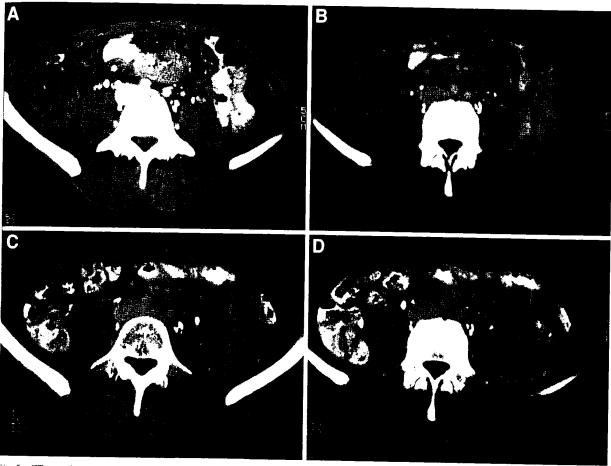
CT scan images of patient 8 from two comparable levels before treatment (A and B) and 5 months after treatment (C and D), showing resolution of a large mesenteric mass
